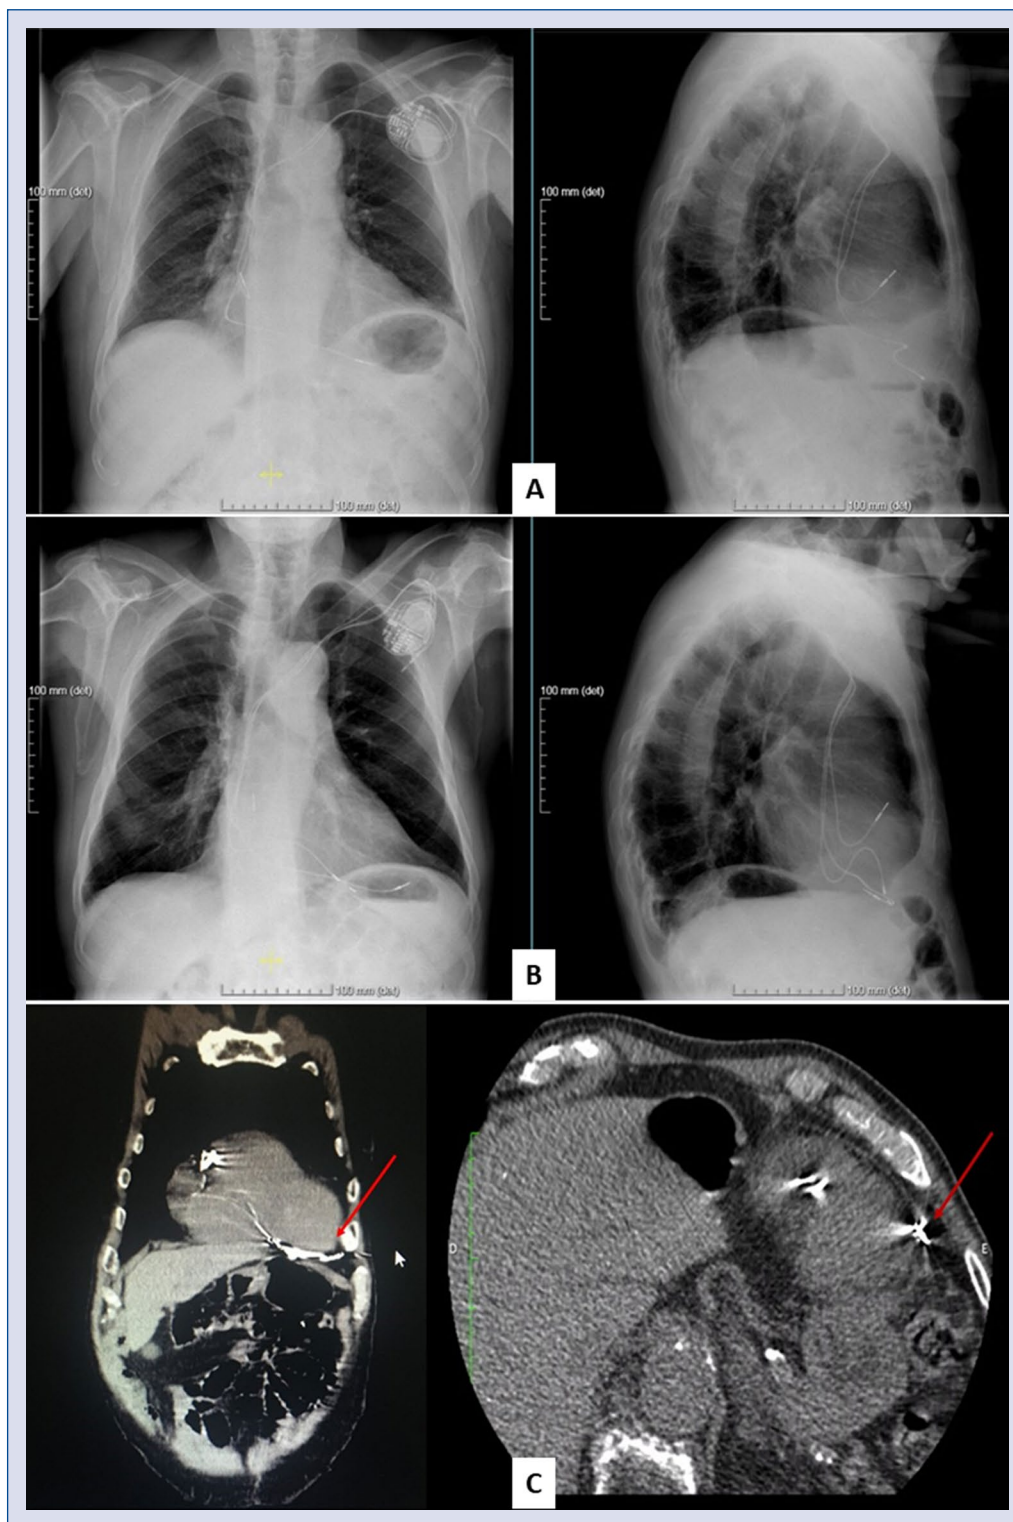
A. First implantation; on discharge date: thorax X-ray showing normal positioning of atrial and ventricular leads and absence of pleural complications; B. After surgical review, a new ventricular lead is implanted; on discharge date: thorax X-ray showing a new lead in normal position, and the old one displaced within the cardiac silhouette; C. Cardiac computed tomography: showing right ventricular apex perforation by a ventricular lead located beneath the left ventricle's inferior wall and apex (arrows).
